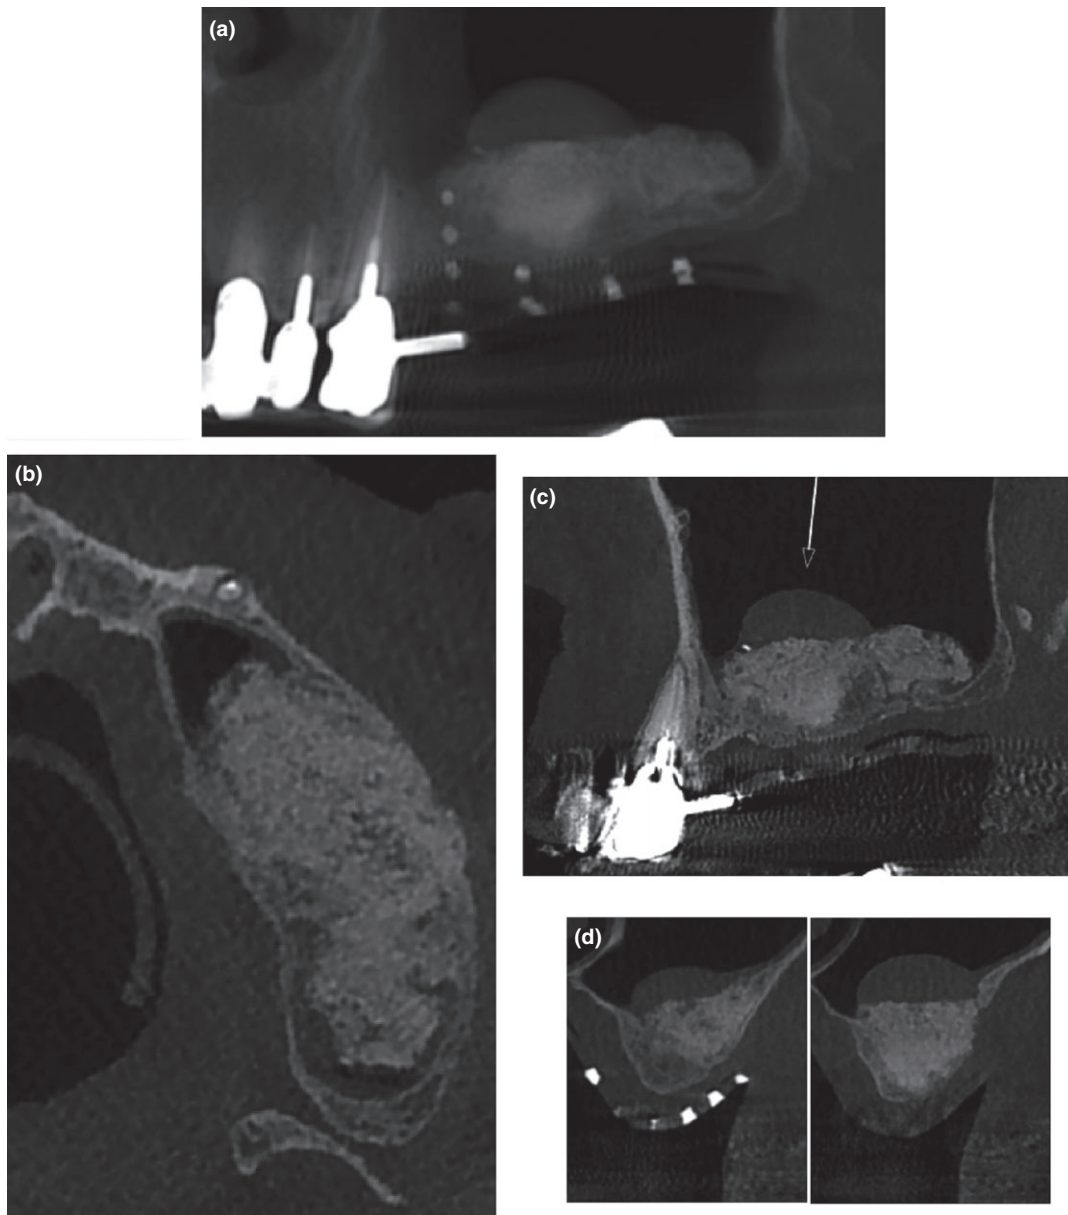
Cone beam CT pre-implant assessment. Six months after the bone graft, cone beam CT provides information on bone graft osseointegration (a-c), maxillary sinus complications (c), and provides radiological guidance for pre-implant assessment (d).
